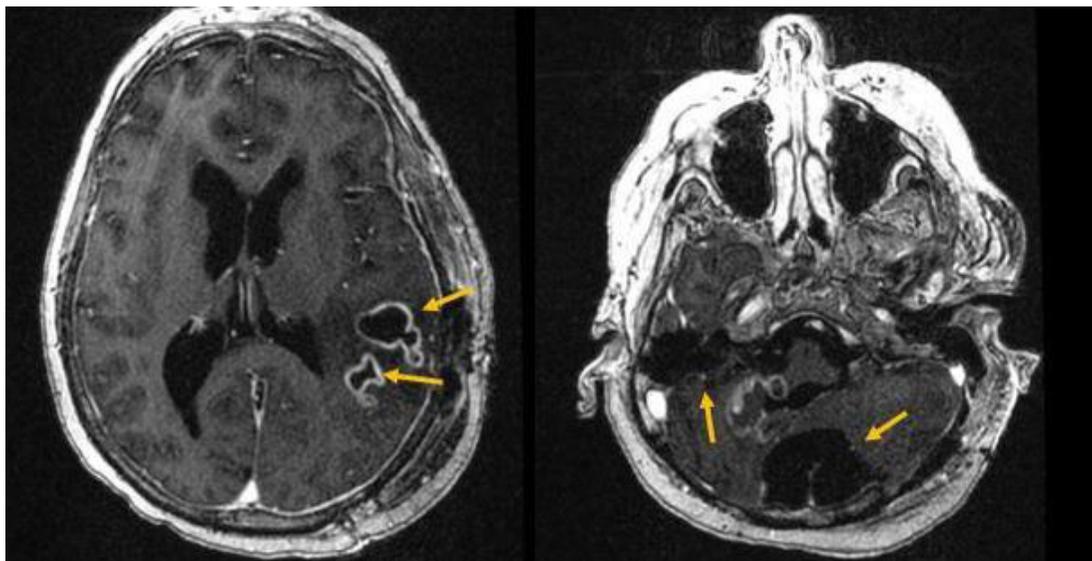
Ring enhancing cerebral lesions (arrows) are demonstrated within the left cerebellum, left temporo-parietal junction, left para-median superior parietal lobe, and right cerebellum on T-1 weighted magnetic resonance imaging of the brain, taken 15-months after brain mass resection.
